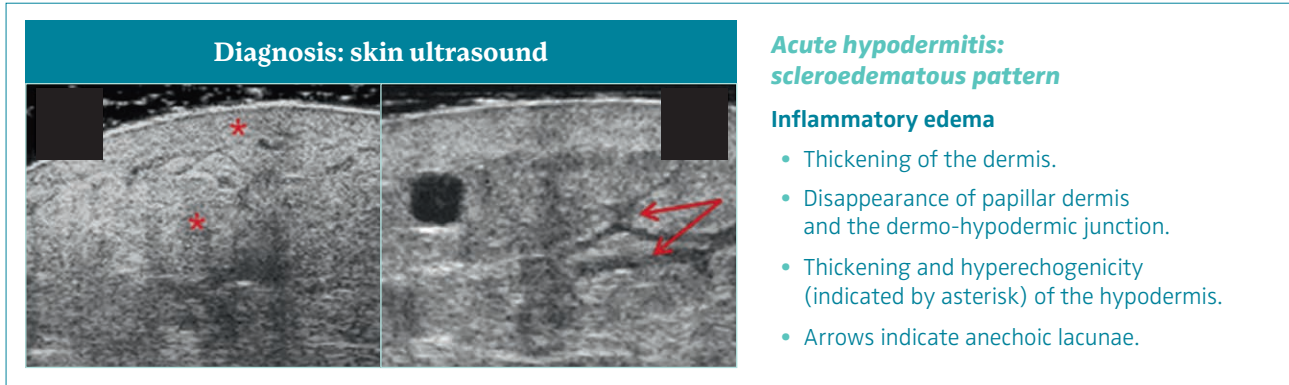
Skin ultrasound of acute hypodermitis: scleroedematous pattern. Ultrasonography of skin changes in legs with chronic venous disease.
